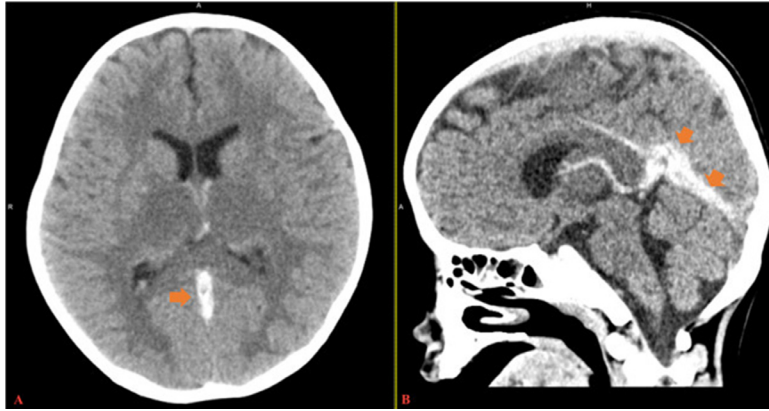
Computed tomography images. (A) Shows an axial cross-section of the thalamus showing bilateral hypodense thalamic lesions. (B) shows the hyperdense cerebral venous sinus system (orange arrow).
